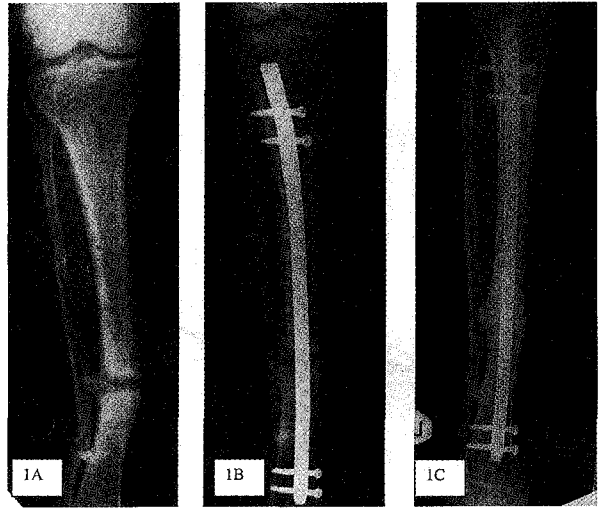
A case of closed fracture tibia treated with plate and screw complicated with acute infection and finally non-union. Radiograph of closed reamed interlocking nail with fibular osteotomy at three months showed bridging of callus (B) and six months later complete osseous transformation of fibrous fracture gap. (C)
